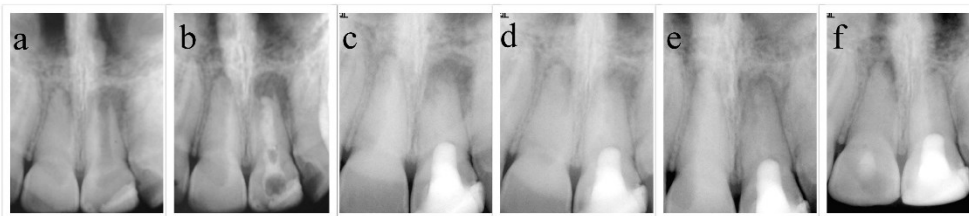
Periapical radiographic images. a) pre-operative radiograph b) immediate obturation film c) 3-month follow-up d) 6-month follow-up e) 12-month follow-up f) 24-month follow-up
